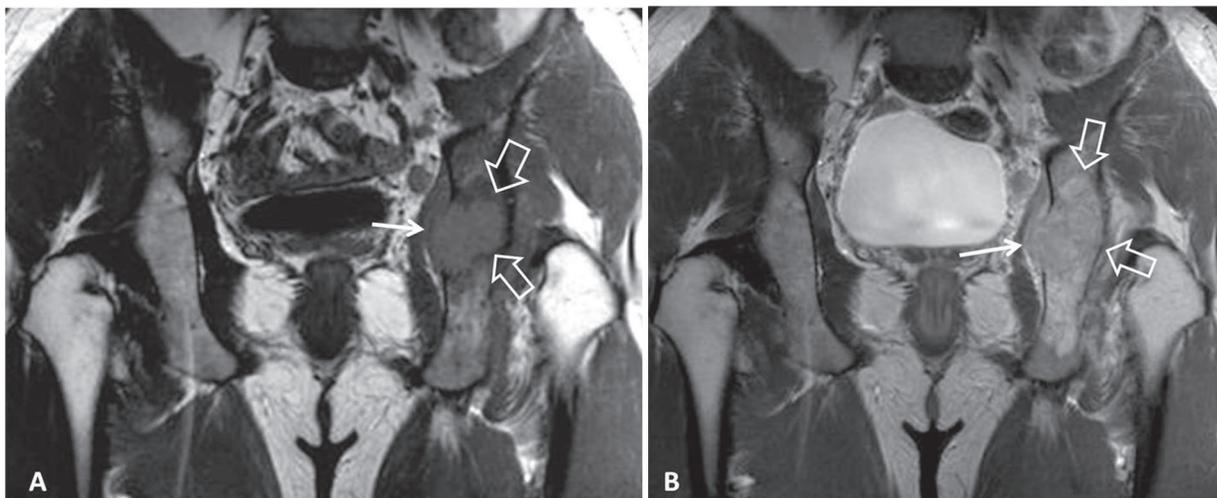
A 25-year-old male patient with primary bone non-Hodgkin lymphoma of the acetabulum. Coronal T1w (A) and contrast-enhanced T1w (B) MR images showing a large, low-signal intensity and enhancing lesion of the left ischial bone (open arrows). The lesion is expansile and there is extension through the disrupted cortex to the soft tissues medially (arrows).
